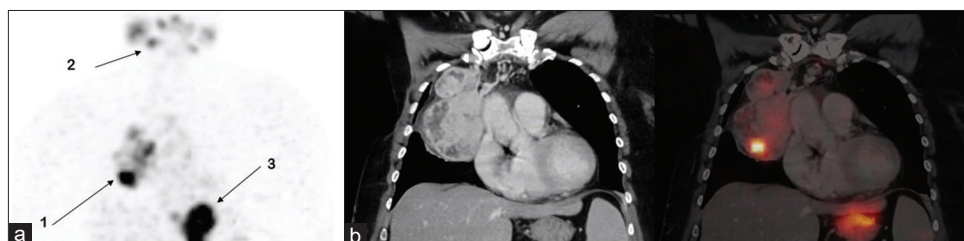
Images using 83 MBq (2,2 mCi) $^{99\text{m}}\text{Tc}$ sodium pertechnetate. (a) Maximum intensity projection visualizes accumulated activity in the intrathoracic thyroid tissue (arrow 1), in the salivary glands (arrow 2) and in the stomach (arrow 3). (b) Computed tomography with intravenous contrast and fused images as in Figure 1
